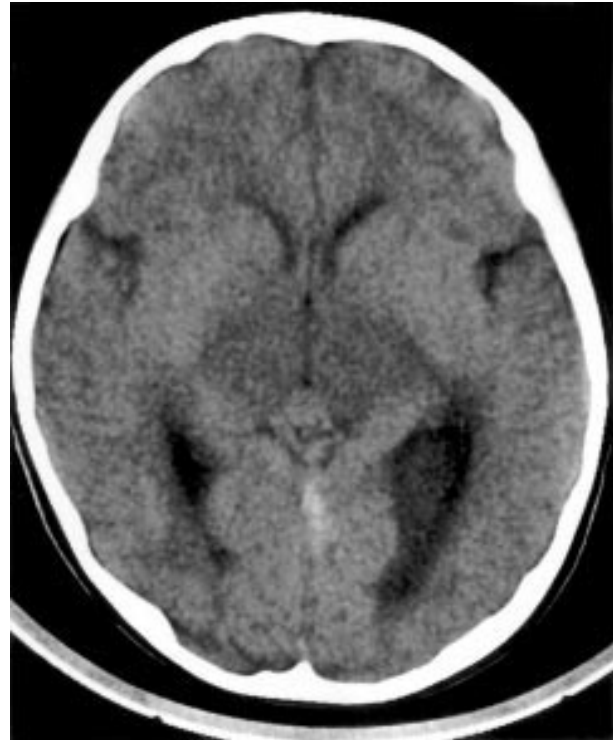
CT scan showing increased echogenicity in straight sinus, confirming presence of thrombosis. Also note control hypodense areas consistent with basal ganglia infarction.
